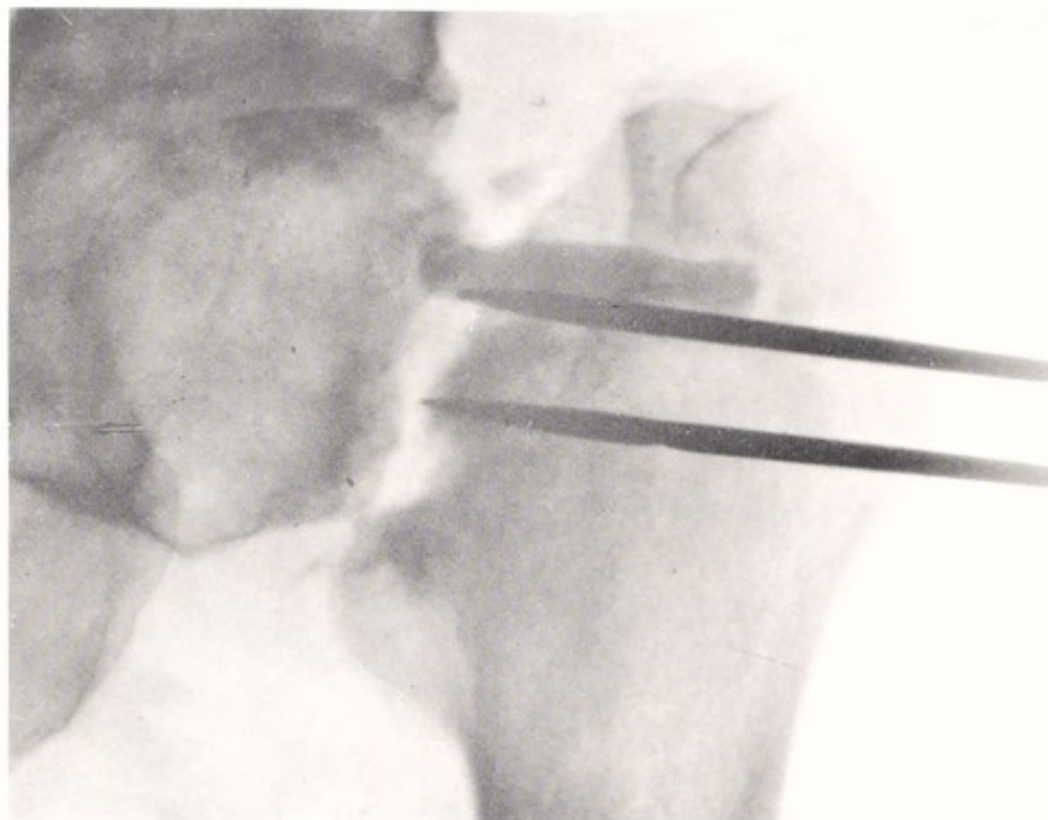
Boiled ox-bone was first inserted. It broke and absorbed, leaving fragment shown just above nails which were inserted two months later in an added effort to secure union. A loose non-union is disclosed by x-ray.
